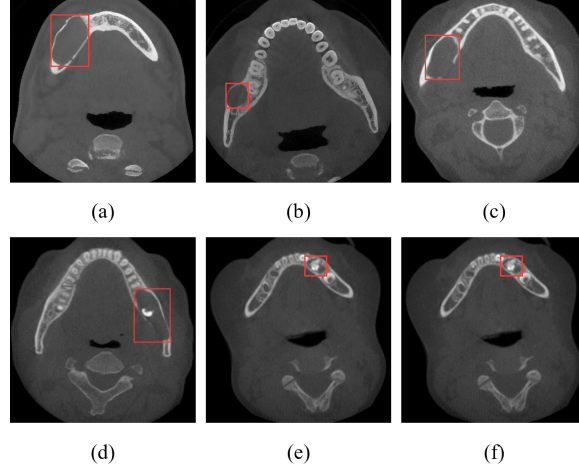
Examples of CBCT images, with lesion areas marked in red boxes, (a)-(d) represent cystic lesions, (e) represents a solid lesion, and (f) is a mixed lesion.
